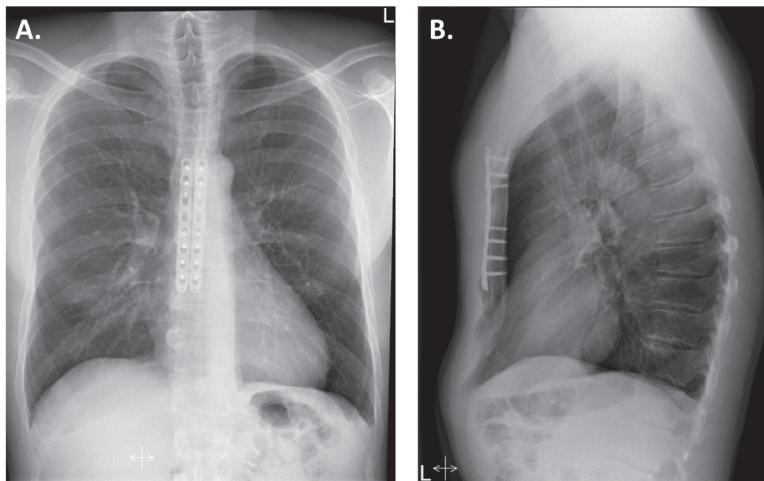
Postoperative chest X-ray after locking compression plate osteosynthesis.
